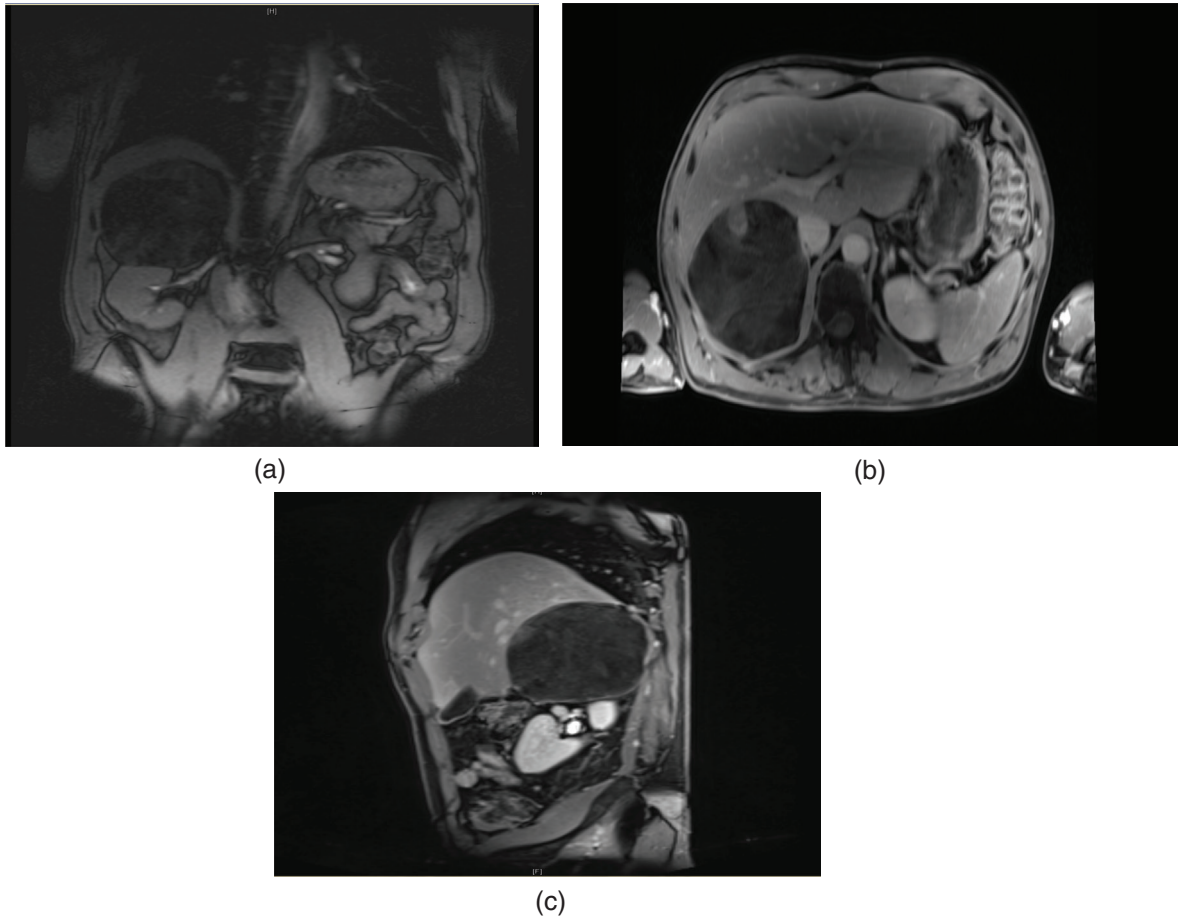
(A) MRI appearance of myelolipoma. (B) MRI appearance of myelolipoma. (C) MRI appearance of myelolipoma.
